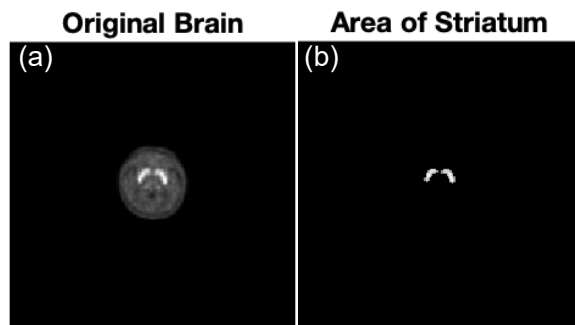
Image segmentation of patient No.2 by using Otsu's Algorithm with gray scale. (a) Original PET/CT imaging and (b) image segmentation of striatum.
